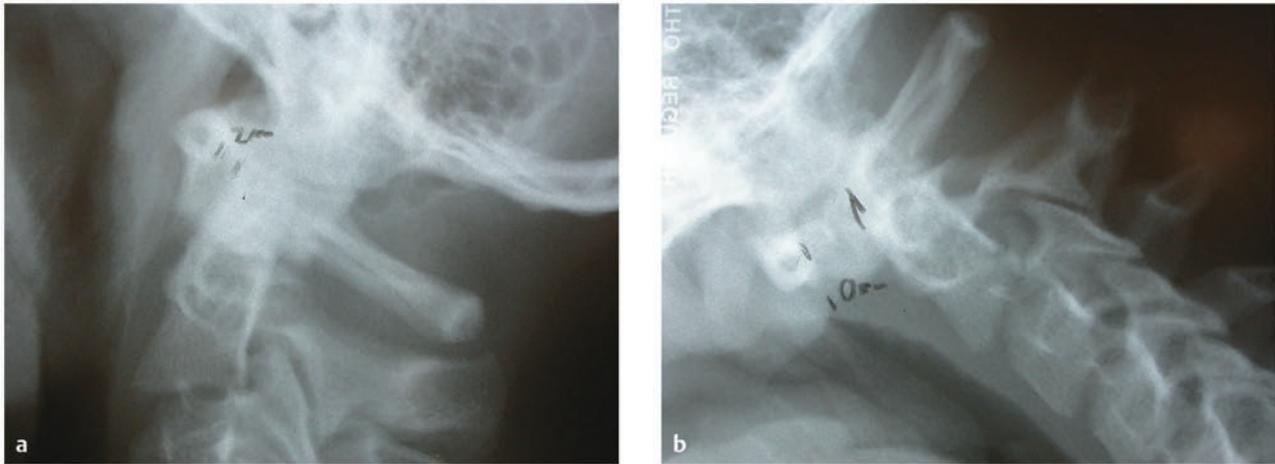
Translational C1–2 subluxation. (a) Extension and (b) flexion radiographs demonstrating an atlantodental interval of 2 mm on extension and 10 mm on flexion, indicative of atlantoaxial instability in a 13-year-old boy following an assault to the head.
